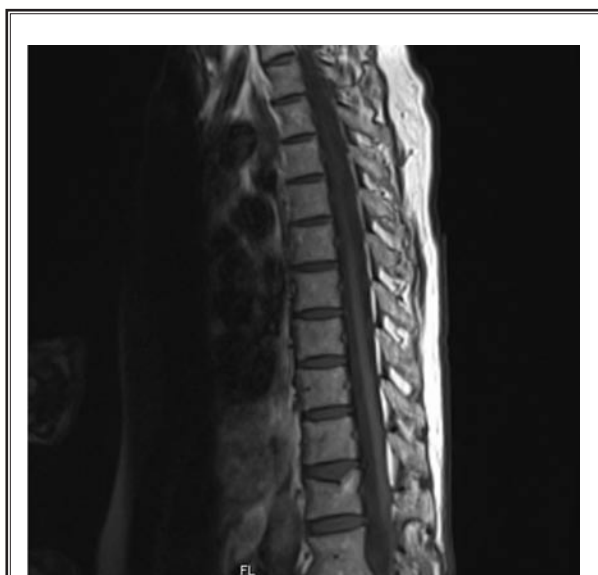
T1-weighted image of T12 hemangioma located at the posterior vertebrae near the superior end-plate fracture.
